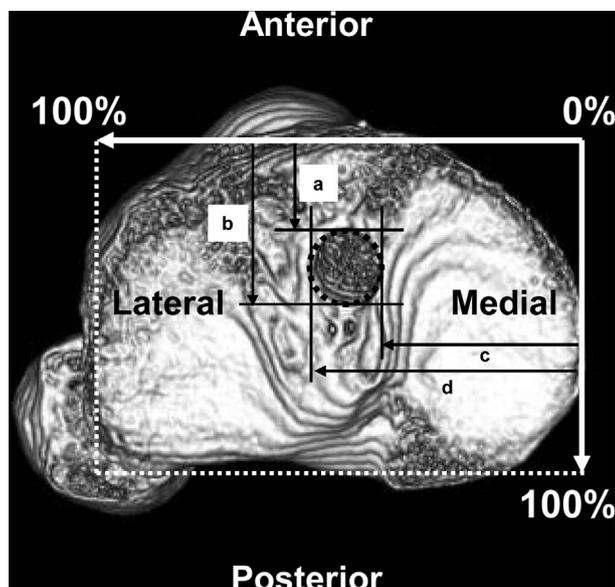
Computed tomography image of the proximal tibia showing the measurement of the location of the tibial tunnel walls using the anatomical coordinate system [23,30,31]. The black dashed line indicates the tibial bone tunnel. The distance from the anterior border to the posterior border of the tibial condyle was defined as 100% for the anterior–posterior measurement, while the distance from the medial border of the tibial condyle to the lateral border of the tibia was defined as 100% for the medial–lateral measurement. (a), (b), (c) and (d) are the positions of anterior, posterior, medial and lateral tunnel walls, respectively. The tunnel wall positions in the anterior–posterior and medial–lateral directions were calculated as percentages of these distances.
